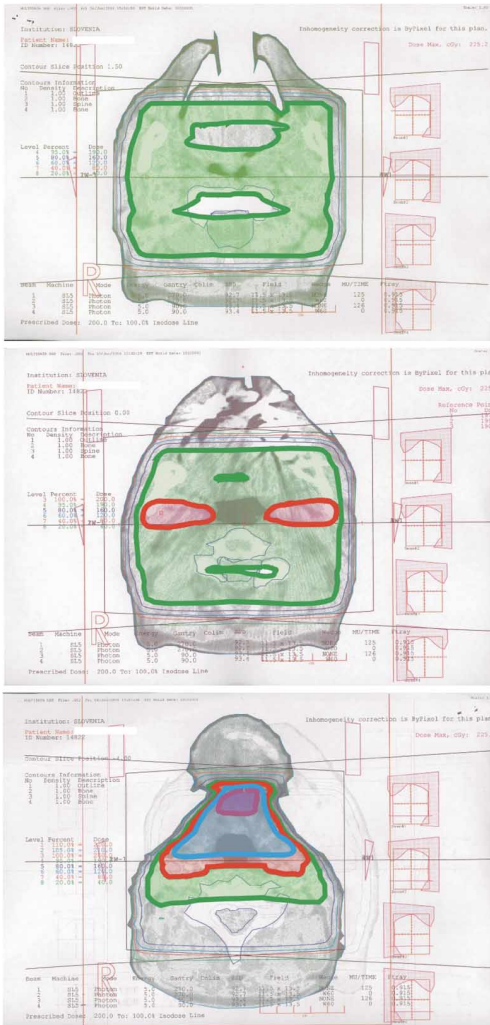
The optimized dose distribution was calculated using three CT slices (see Fig. 1). Applying only wedge filter compensators, the calculated inhomogeneities inside the treated volume were significant. The regions of different absorbed doses, expressed in the percentage of prescribed dose, are colored: 95 % ≤ green <100 %; 100 % ≤ red <105 %, 105 % ≤ blue <110 %, 110 % ≤ purple < 115 %. On the central slice (through isocenter), the dose varied from 95% to 100% of prescribed dose. On the lower slice (4 cm below isocenter), the absorbed dose exceeded 110% of the prescribed dose. On the upper slice (1.5 cm above isocenter), the absorbed dose hardly reached 95 % of the prescribed dose. The planned overall inhomogeneity range applying only wedge filter compensators was 19 % of the prescribed dose.
